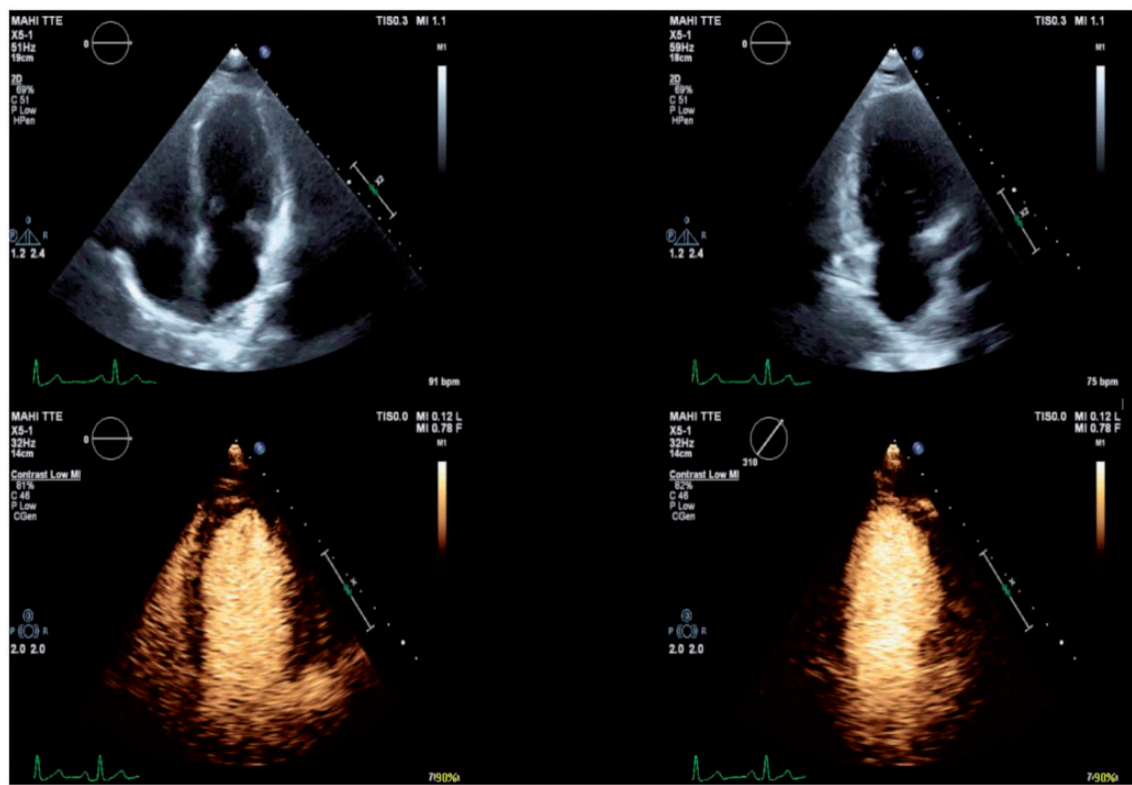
Apical four- and two-chamber views (top left and right) with poorly visualized borders between the compact and trabeculated myocardium. The corresponding recording obtained after injection of contrast agent (0.5 mL SonoVue[®]) show adequate delineation of the LV cavity from the myocardium (bottom left and right).
